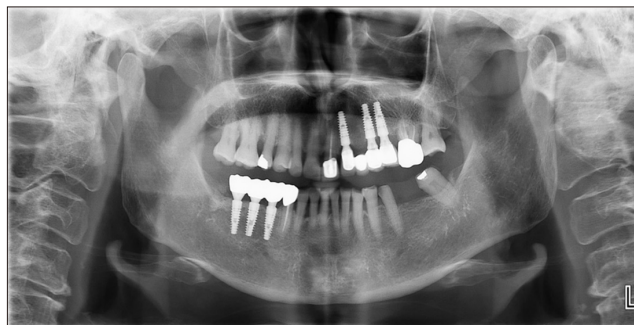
Panoramic radiograph (case 2) showing moderate alveolar bone loss in the left maxillary and mandibular areas. No pathologies that could cause pain were identified.
